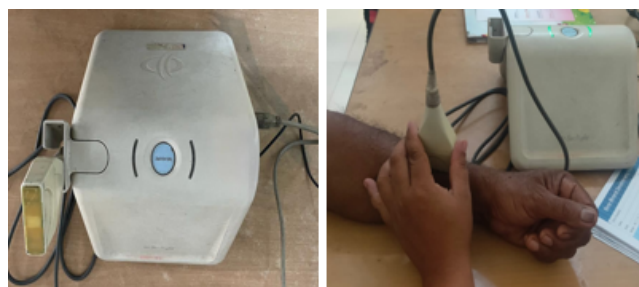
T-score measured using ultrasonic bone densiometer at distal radius
